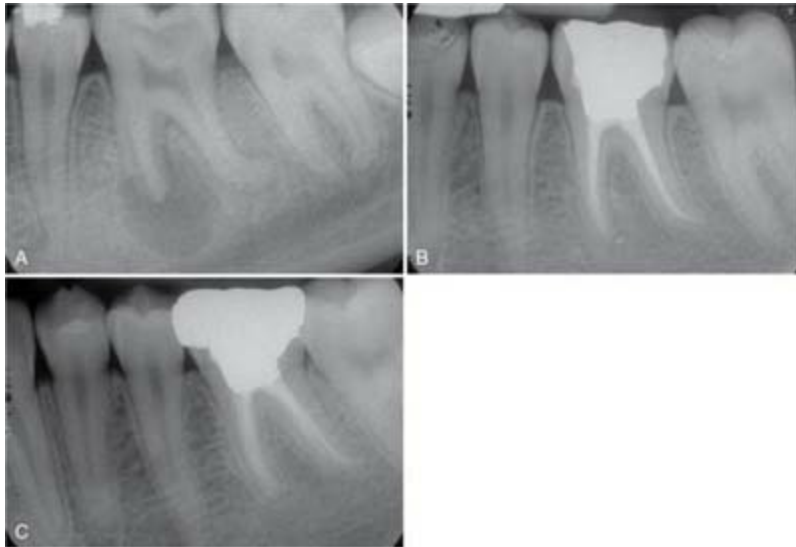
Resolution of periapical disease after root canal treatment of the mandibular left molar with preoperative periapical radiolucency associated with mesial and distal roots (A), delayed healing caused by extruded filling material from the distal canal (B) and nearing complete healing as extruded material is resorbed (C).
